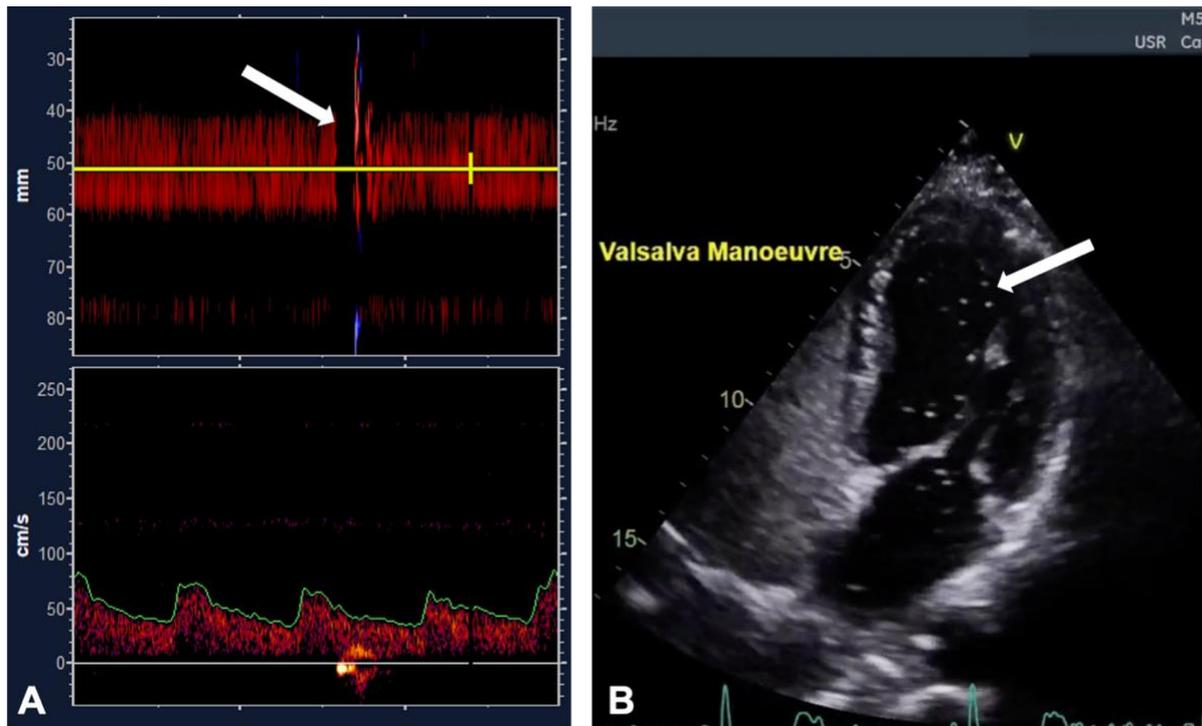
(A) TCD of the middle cerebral artery, arrow points at a potential microbubble travelling through the artery. (B) TTE of the heart (apical 4-chamber view), arrow indicates a microbubble in the LV, indicating the presence of a PFO. Abbreviations: TCD = transcranial Doppler, TTE = transthoracic echocardiogram, LV = left ventricle, PFO = patent foramen ovale.
